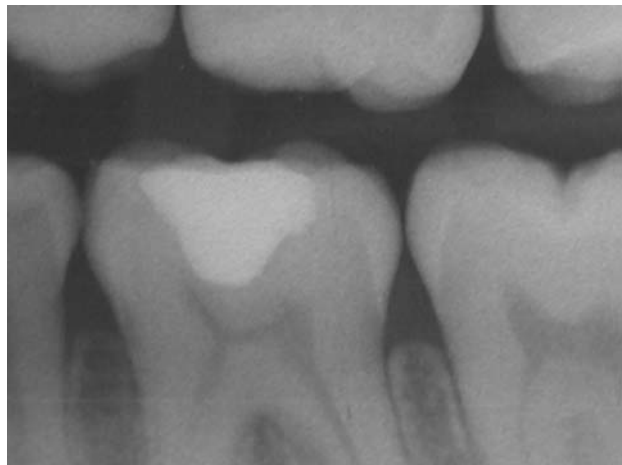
The postoperative radiograph revealed the extent of the depth of the cavity. The authors consider that if the operator had removed most of the infected caries on the floor of the cavity on the first visit that there would have been a high probability that a root canal therapy may have been required.
